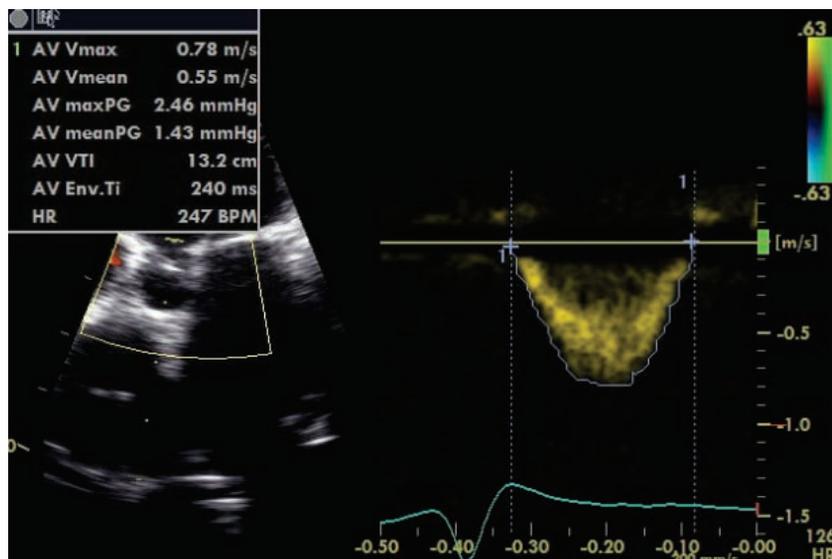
Echocardiographic measurement method of Ao-VTI.
